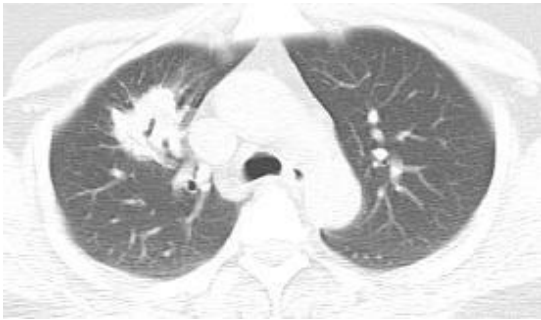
Initial CT of the chest with contrast showing a lobulated lesion in right upper lobe measuring approximately 3 cm in the greatest diameter.
